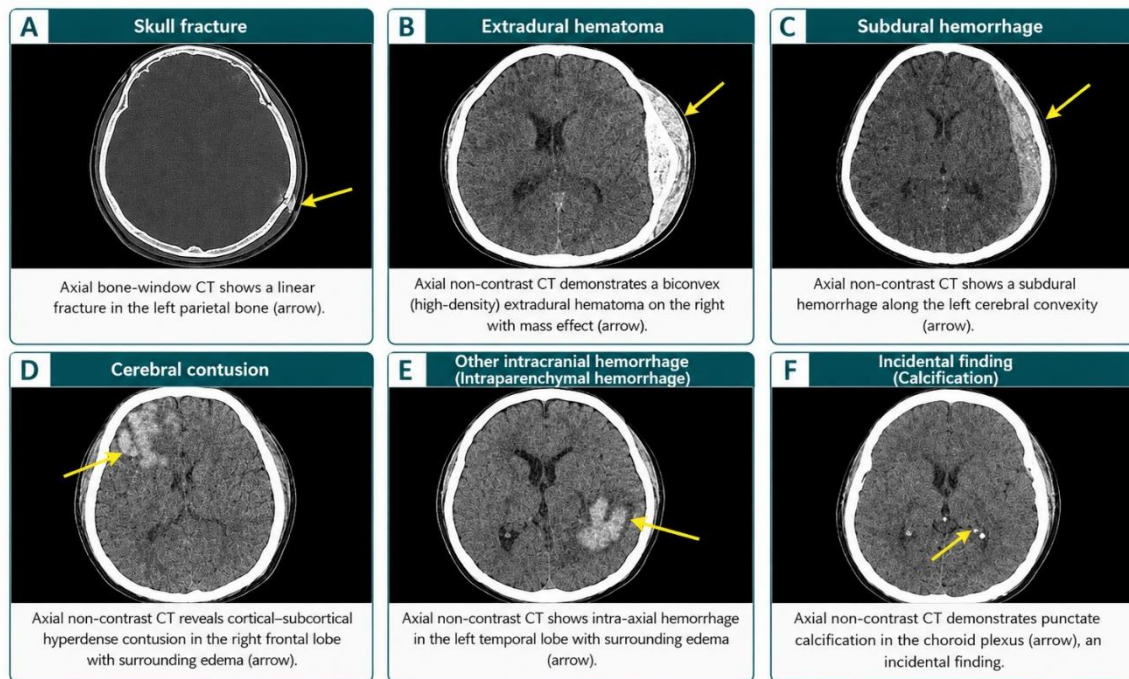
The multipanel figure presents representative axial non-contrast CT findings in pediatric patients following accidental falls, including a linear skull fracture, extradural hematoma, subdural hemorrhage, cerebral contusion, intraparenchymal hemorrhage, and incidental choroid plexus calcification, with arrows indicating the principal radiological abnormalities in each panel.
